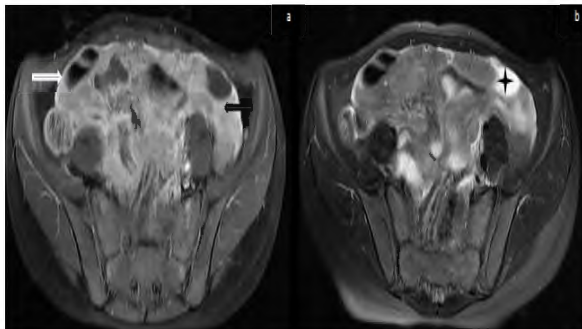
On enhanced axial T1-weighted and T2-weighted series (a,b), heavily enhanced soft tissues that could not be limited clearly and not partially distinguished in terms of the borders with bowel loops, and surrounding the bowel loops on mesenteric and omental fatty tissue were visualized (black arrow). Peritoneal surfaces were thickened, and specific enhancement was present on pelvic fatty tissue (white arrow). Minimal free fluid adjacent to bowel loops was noticed (asterisk).
